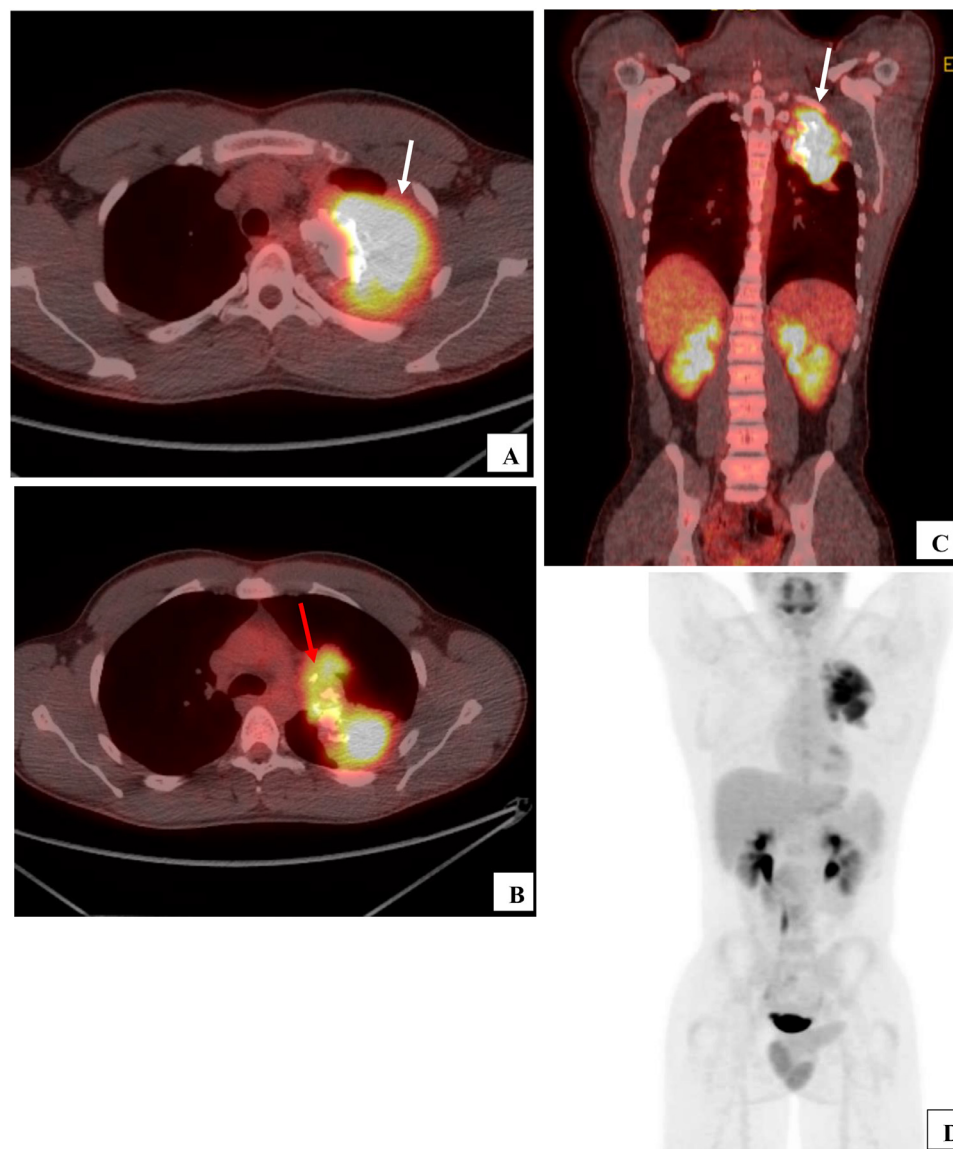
A 22-year-old male with a left chest apical mass, suspicion of a malignant process. Fluorodeoxyglucose (FDG)-positron emission tomography (PET) scan demonstrates a heterogeneously FDG avid partially calcified irregular mass in the upper lobe of the left lung (A, C – white arrow), confluent with hypermetabolic ipsilateral hilar lymphadenopathy (B – red arrow). No additional suspicious FDG avid lymph nodes or distant metastasis were identified (D).
